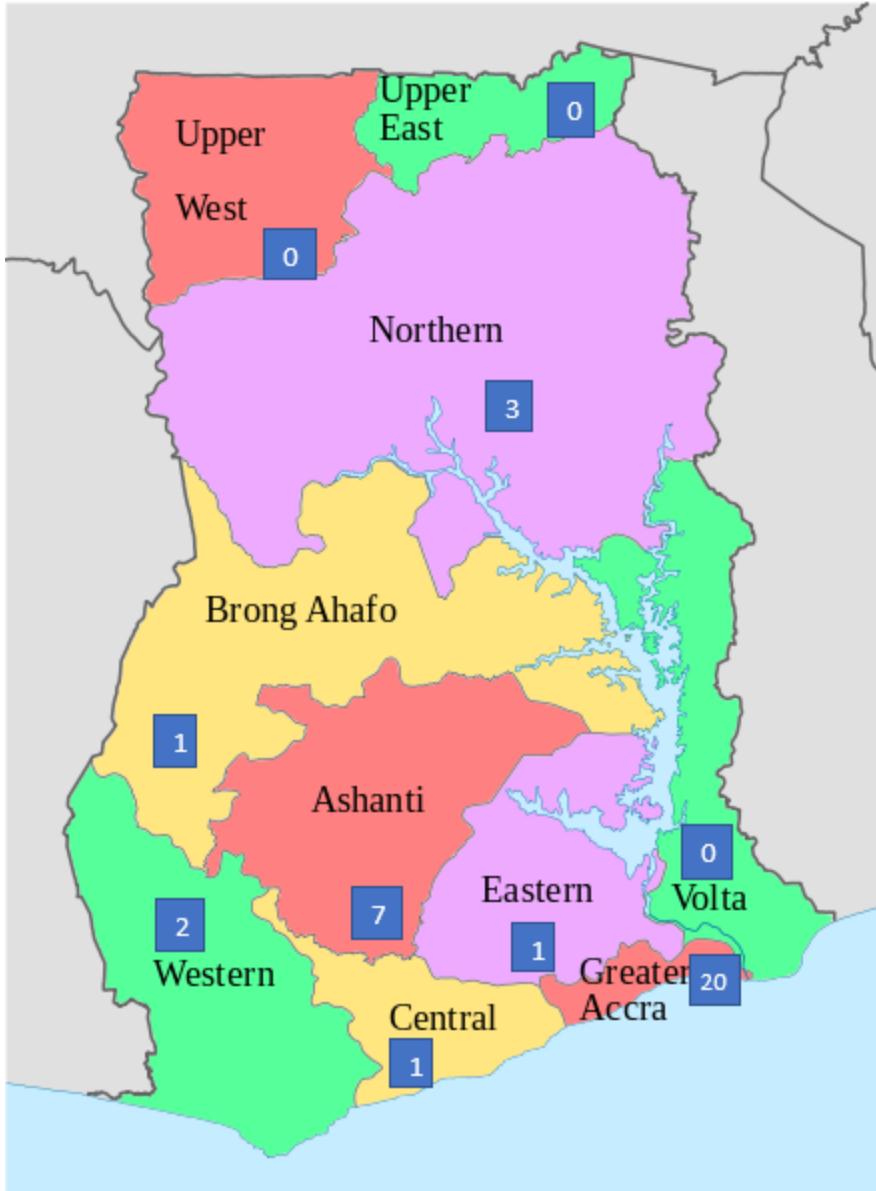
Regional distribution of CT scanners in Ghana as at December 2017
